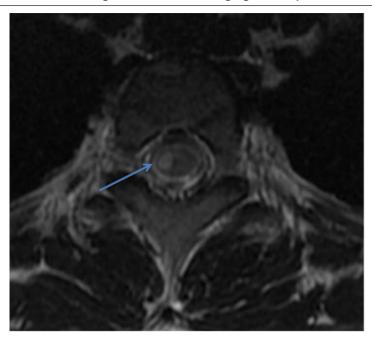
Transverse section of the magnetic resonance imaging of the spinal cord
